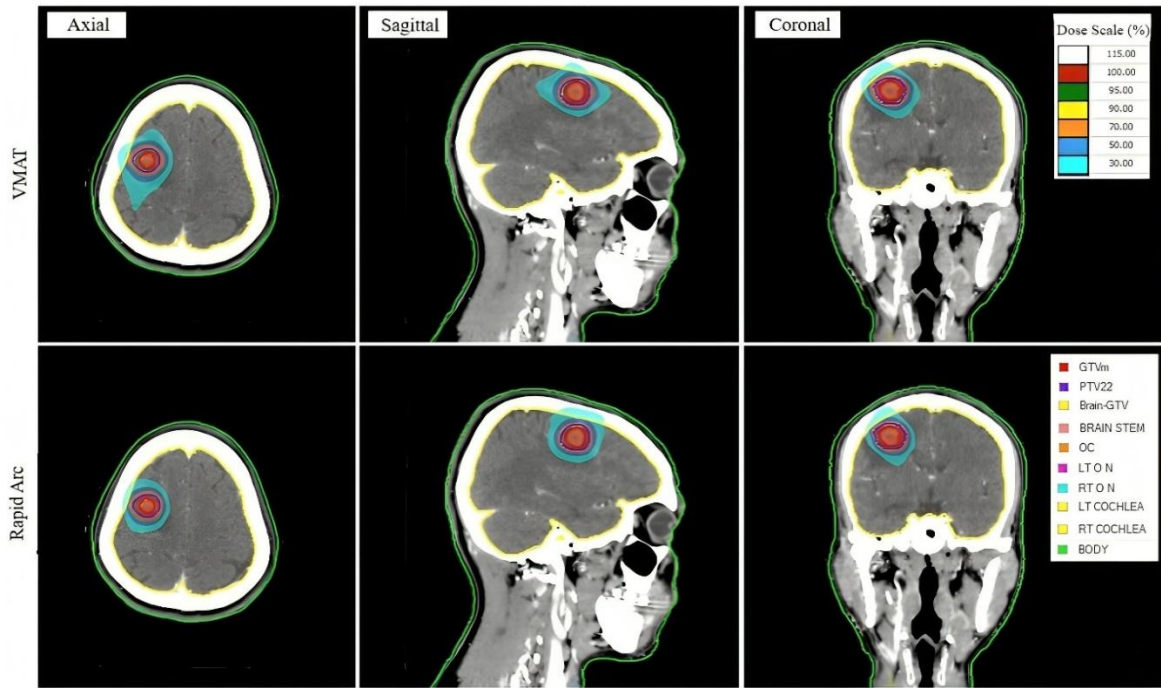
Axial, sagittal, and coronal CT images comparing dose distributions for VMAT (top row) and RapidArc (bottom row) SRS plans for a single brain metastasis case. Dose color wash represents isodose levels as a percentage of the prescription dose. RapidArc demonstrates superior dose conformity and steeper dose fall-off, resulting in reduced intermediate dose spillage to surrounding brain tissue.
